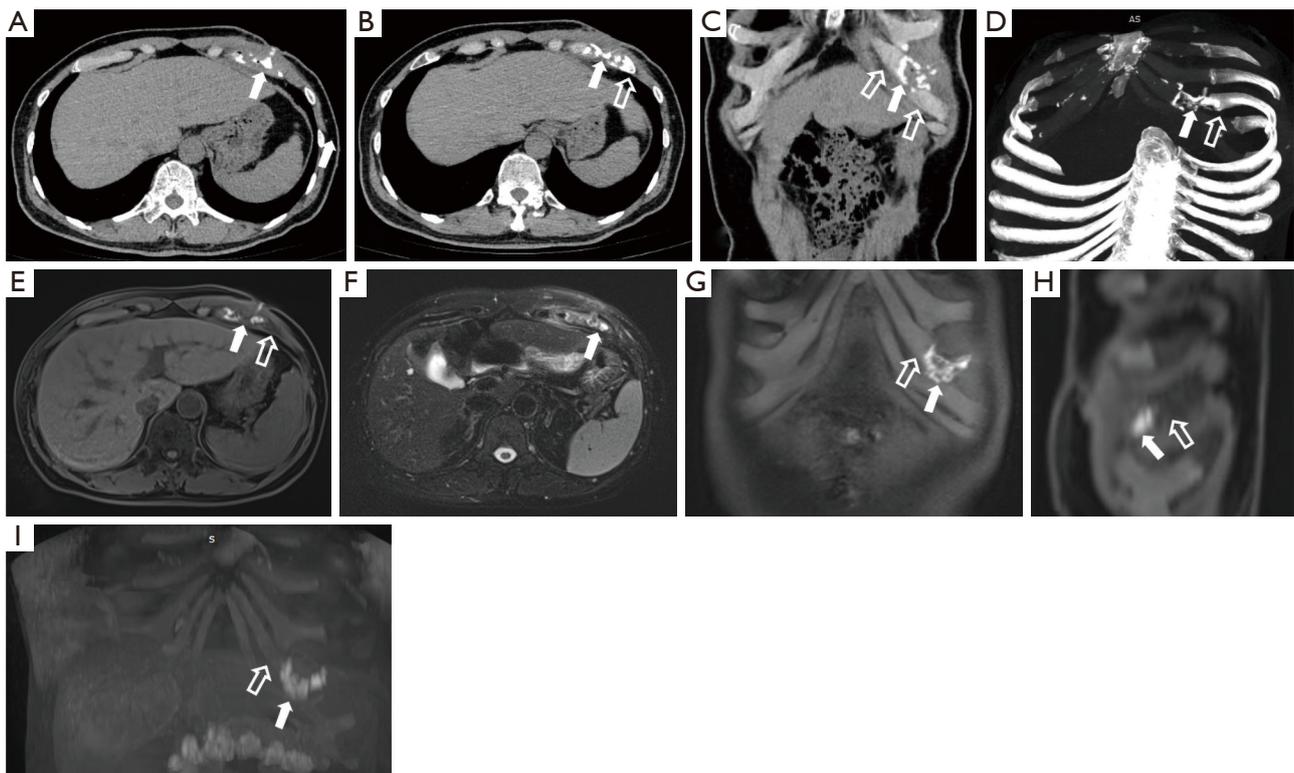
A 56-year-old man diagnosed with abdominal chronic wounds 10 months after abscess incision and drainage. (A-D) CT images of sinography/fistulography, MPR and MIP; (E-G) MR sinography/fistulography images of axial fat-saturated T1w, coronal fat-saturated T1w and axial fat-saturated T2w sequences; (H,I) MR images of MPR and MIP. The chronic wounds (white arrows) demonstrated as a contrast agent filled sinus cavity with small bubbles and surrounding soft tissue edema, involving left rib and costal cartilage (open arrows). CT, computed tomography; MR, magnetic resonance; MIP, maximum intensity projection; MPR, multiplanar reconstruction.
